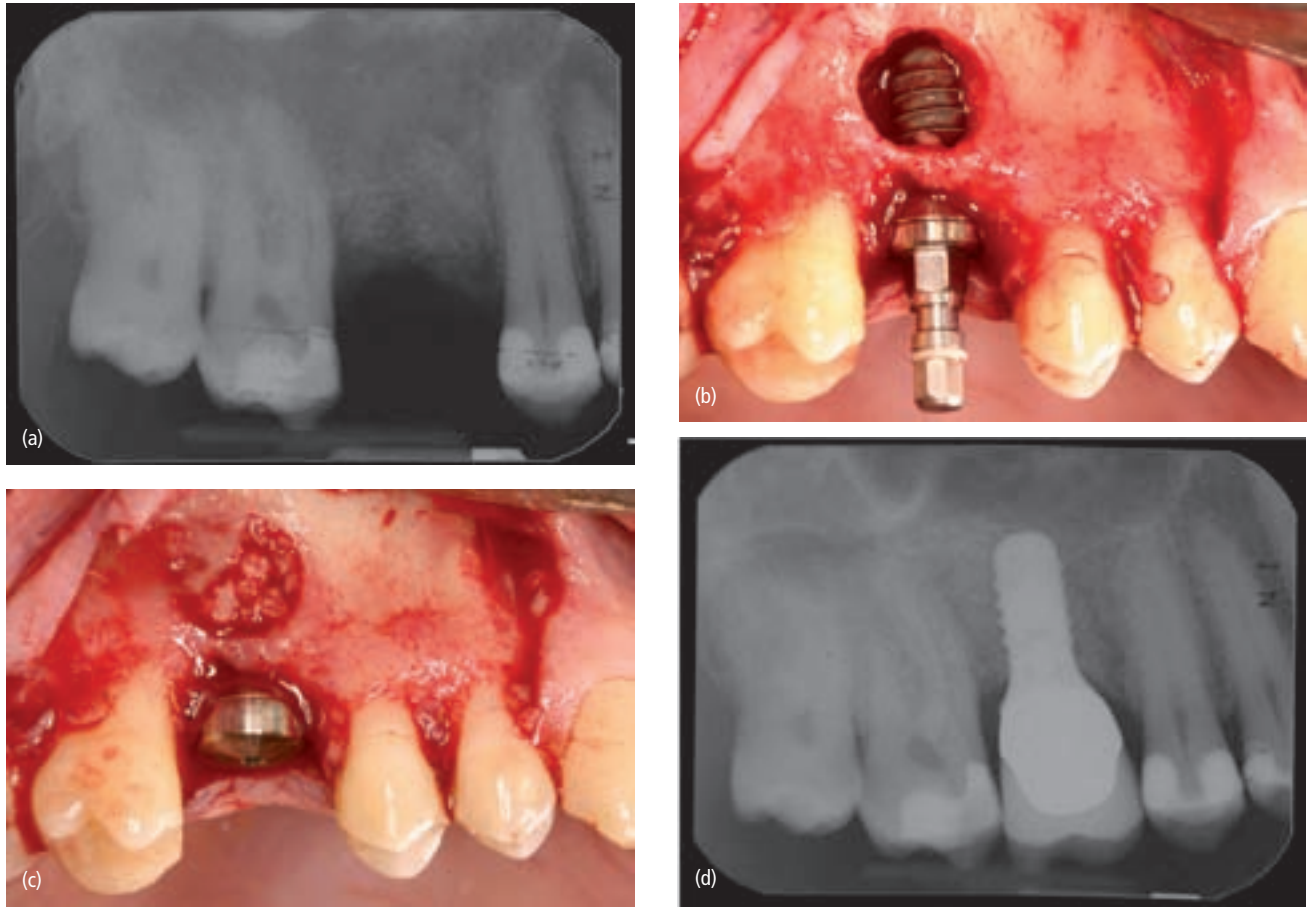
Grafted area failed to calcify: switch to immediate placement with lateral window sinus lift. (a) Initial radiograph. There appeared to be enough bone to carry out a sinus floor elevation. (b) Flap elevation revealed that the crestal bone sloped buccally and there was not enough bone to perform an osteotome sinus floor elevation. (c) A lateral window sinus lift was developed, and bone was placed into window and covered with a barrier. (d) The implant at site 3 was restored 6 months later.
